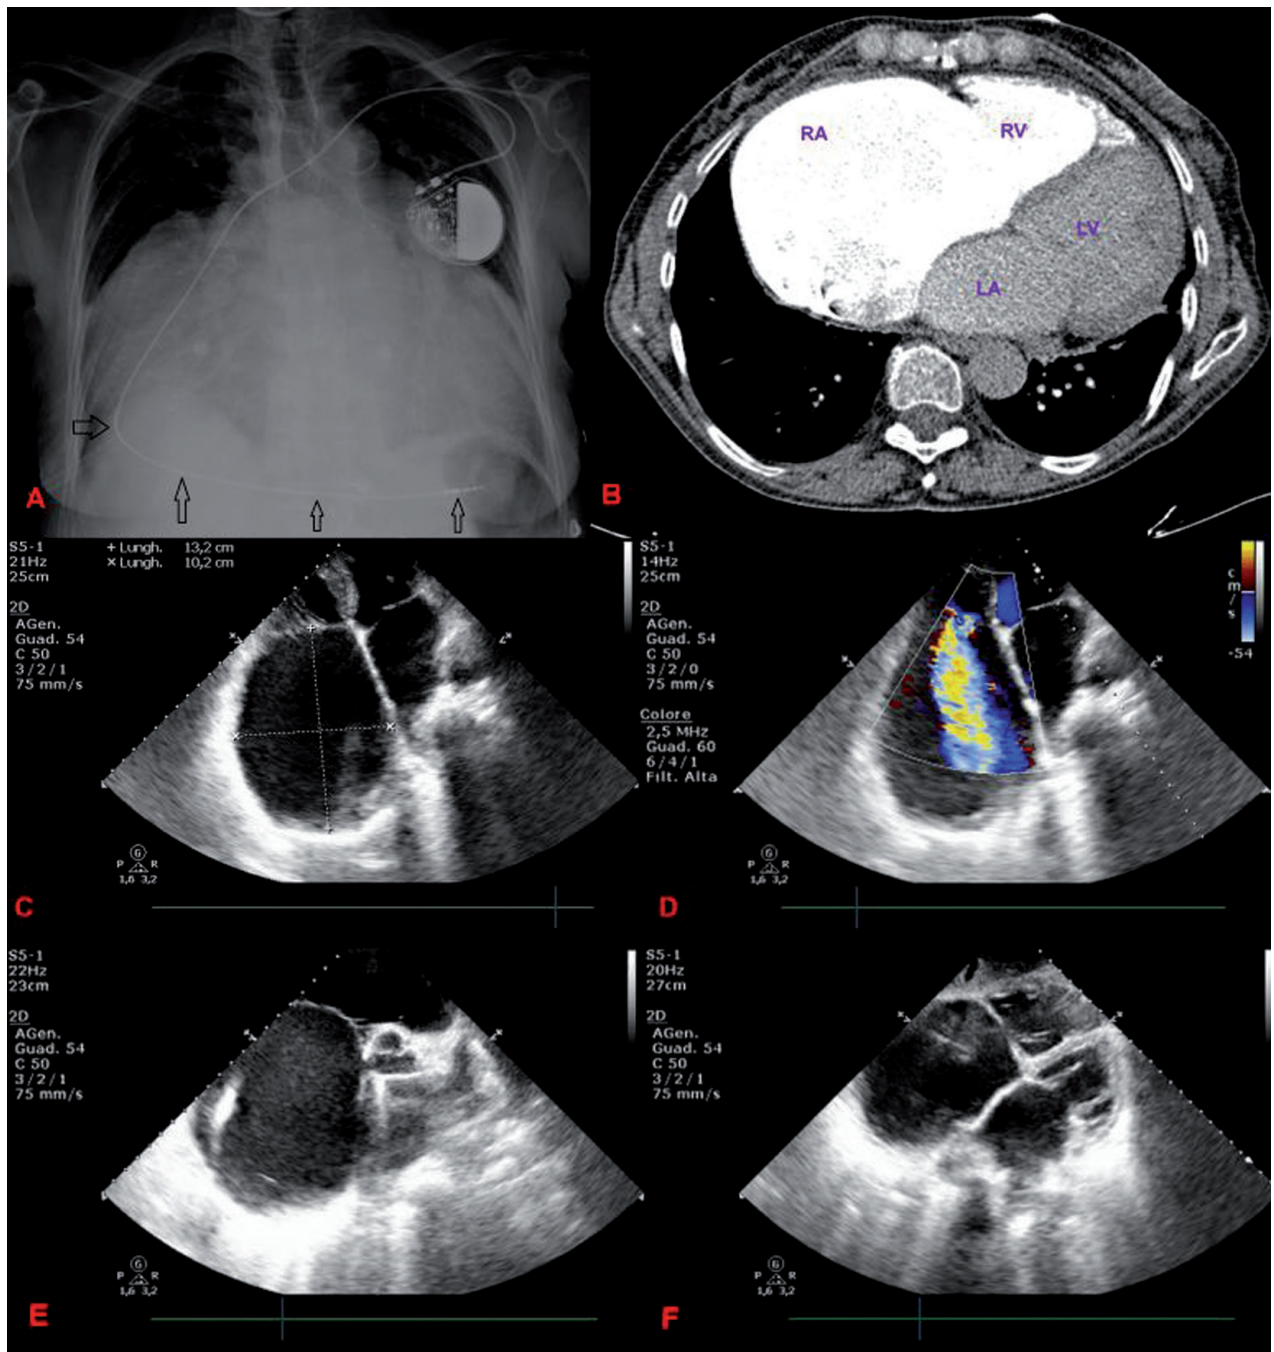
A: A thoracic X-ray showed global cardiac profile enlargement (arrows show intracardiac course of pacemaker catheter). B: Computed tomography, acutely performed in the clinical suspicion of atypical pneumonia/myocarditis or pericardial effusion, showed cardiac enlargement especially of the right chambers. C: Echocardiographic four chambers view showed a giant right atrium. D: Echocardiographic four chambers view showed a giant right atrium with moderate tricuspid regurgitation without stenosis or typical Ebstein's echocardiographic pattern. E: Parasternal short axes echocardiogram view confirmed the severe right atrium dilatation disproportionate to the other chambers. F: Subcostal echocardiogram view confirmed the severe right atrium dilatation disproportionate to the other chambers
